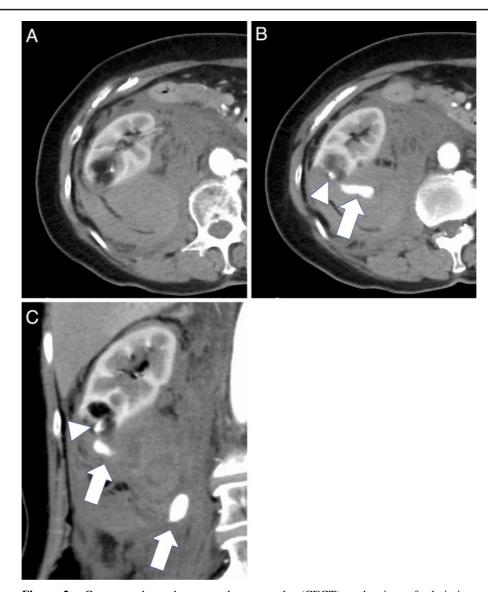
Contrast-enhanced computed tomography (CECT) at the time of admission. The axial cross-sectional images in Figures 2A and 2B, and the coronal cross-sectional images in Figure 3C correspond to the slices in Figures 1A, 1B, and 1C, respectively. CECT shows a retroperitoneal hematoma ($11 \times 14 \times 20$ cm) with contrast media extravasation (2B and 2C, arrow) from a microaneurysm (2B and 2C, arrowhead) in the renal angiomyolipoma.
